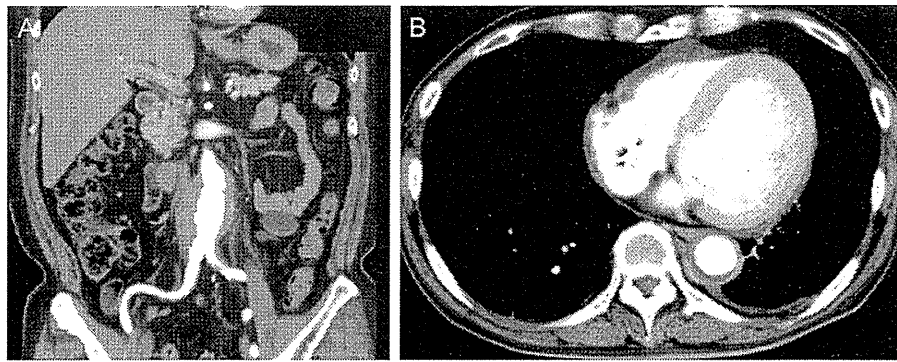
Contrast enhanced computed tomography of chronic periaortitis. (A) Retroperitoneal fibrosis in a reported case [44]. (B) Thoracic periaortitis in a reported case [69].
